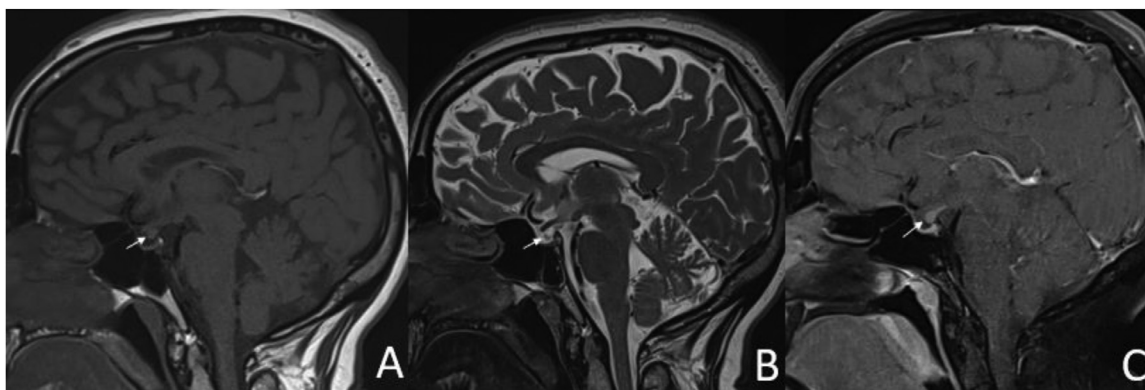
MRI images with sagittal view show an iso intense T1 (A) and hyper intense T2 (B) formation with peripheral enhancement (C) with no continuity with the pituitary gland which is normally located in the Sella turcica (white arrow). There is no abnormal signal within the pituitary gland.
